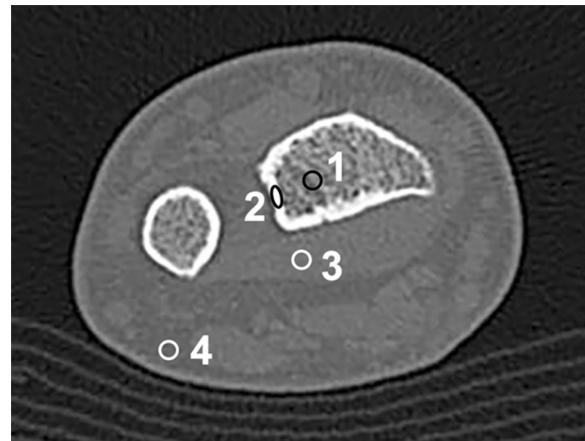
ROI measurements. ROI measurements were performed using small ROIs in the trabecular bone (1), the cortical bone (2), muscle (3) and subcutaneous fat (4), here exemplified by means of a cone-beam CT slice
